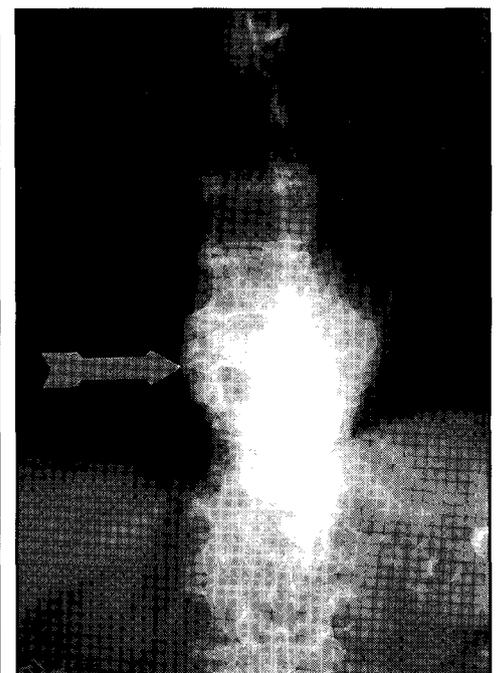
Thoracolumbar x-ray film that shows a calcified vertebral body mass.
